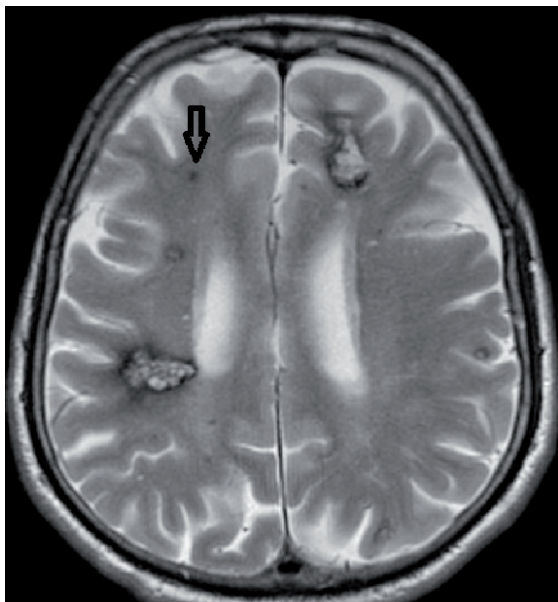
Clearly displayed uniform hyposignal Type III lesion on T2-weighted SE sequence.
